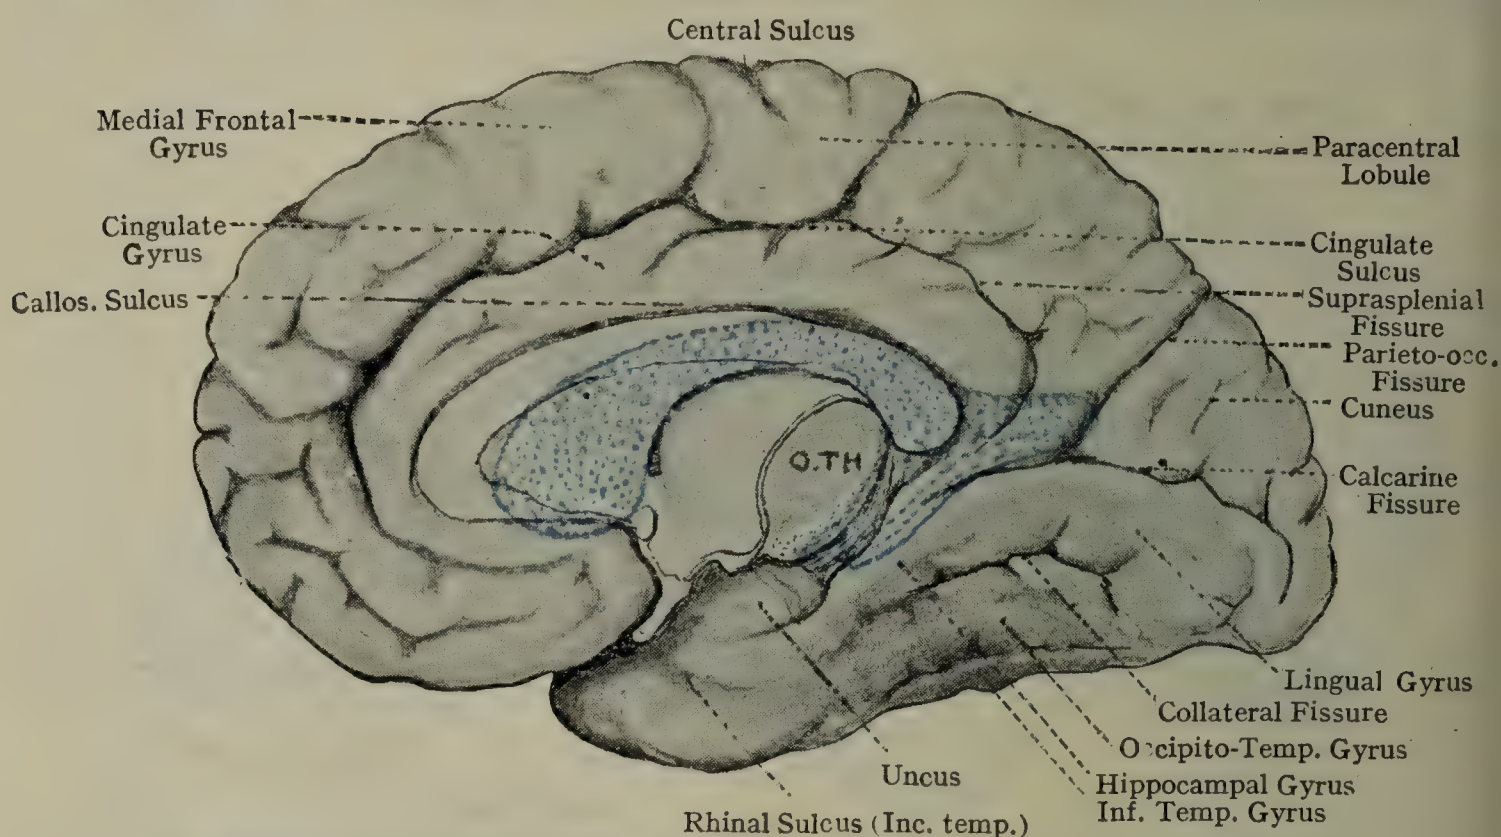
MEDIAL ASPECT OF HEMISPHERE, WITH APPROXIMATE POSITION OF LATERAL VENTRICLE REPRESENTED IN COLOUR.
